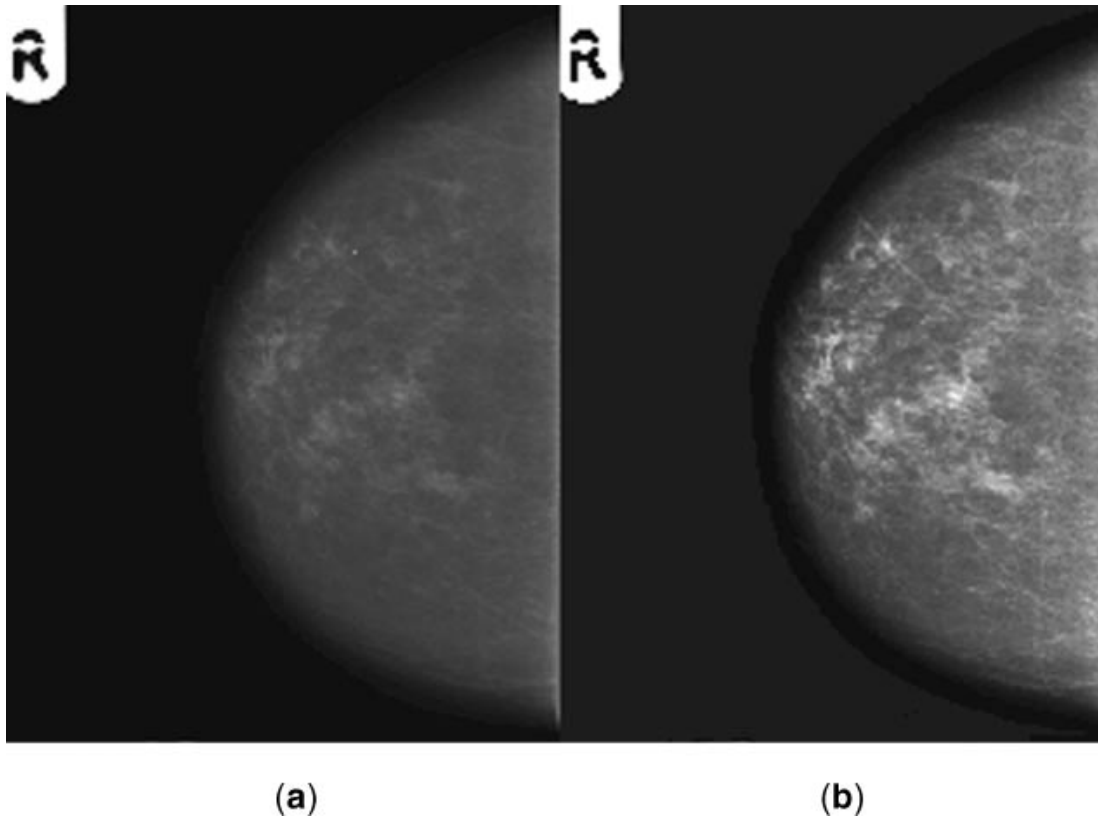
X-ray mammogram (a) before and (b) after physics-based enhancement (95).
